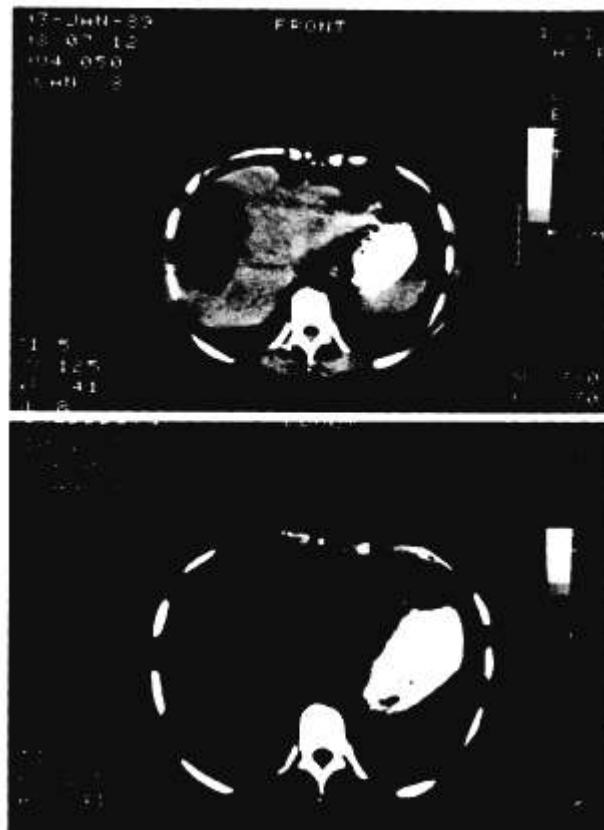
CT scan of the abdomen. Patient no. 13 with 70% regression of her right lobe liver metastases. The top scan was taken on January 13, 1989, and the bottom scan was taken on February 27, 1989.
